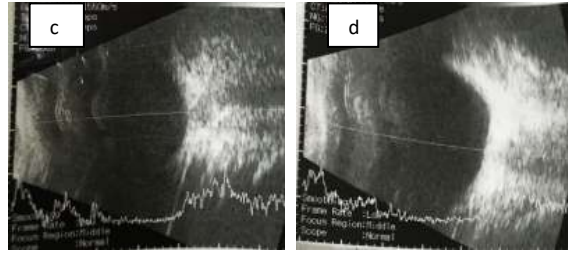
(a). Two months after the corticosteroid was given, rubeosis iris (yellow arrow) developed in her RE. (b). LE complicated cataracts (c and d) Ocular ultrasonography showing exudative retinal detachments had reabsorbed after 3 months of corticosteroid topical and systemic.
